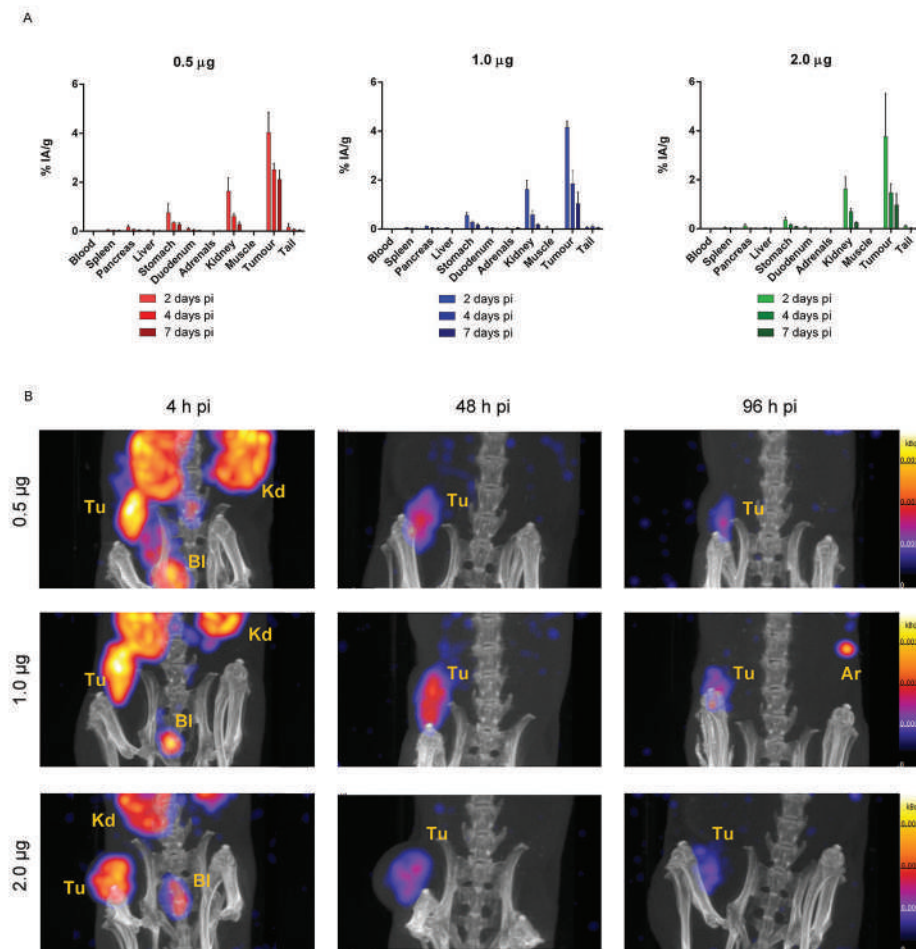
Uptake of ^{177}Lu -TATE applied at different. A: Percentage of injected activity per gram tissue (%IA/g) in tumour and normal organs at 2, 4 and 7 days after administration of 30 MBq ^{177}Lu -TATE: 0.5 µg peptide (red), 1.0 µg peptide (blue), 2.0 µg peptide (green); B: Uptake of radioactivity shown by the SPECT/CT scans (corrected for decay) after injection with 0.5, 1.0, 2.0 µg of ^{177}Lu -TATE. Images are acquired at 4, 48 and 96 h pi. Tu: tumour; Kd: kidney; Bl: bladder; Ar: artefact.
